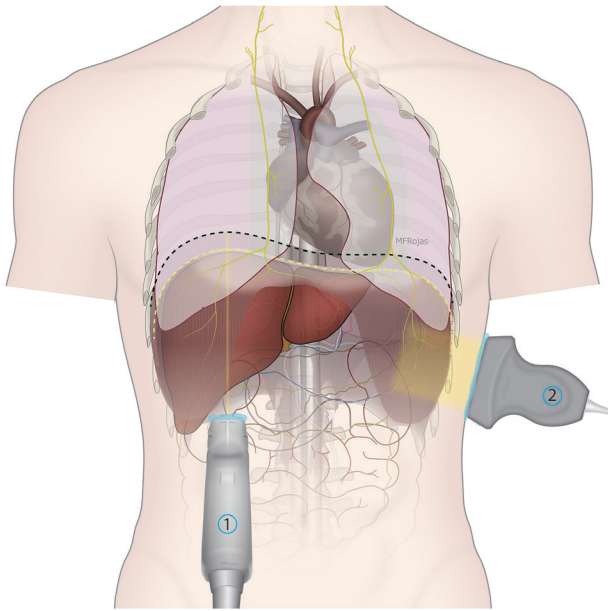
Diaphragmatic ultrasound. Curved array transducer (1) position for scanning the diaphragm in the midclavicular, right subcostal margin using the liver as an acoustic window, and linear array transducer (2) on the left in the midaxillary line at the level of ribs eight to nine. Image reproduced with permission from Maria Fernanda Rojas Gomez and Ultrasound for Regional Anesthesia (USRA; <http://www.usra.ca>).
